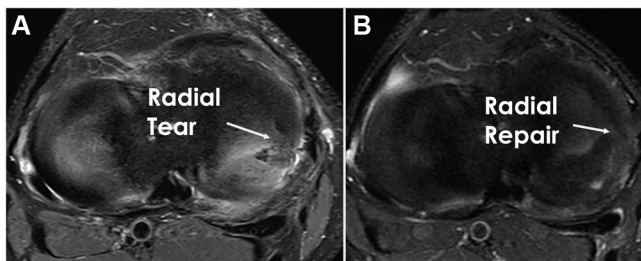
(A) Preoperative fat-suppressed magnetic resonance imaging (MRI) of a right knee consistent with a radial medial meniscus tear. (B) Postoperative fat-suppressed MRI of a right knee showing the repair of a radial tear in the medial meniscus.
